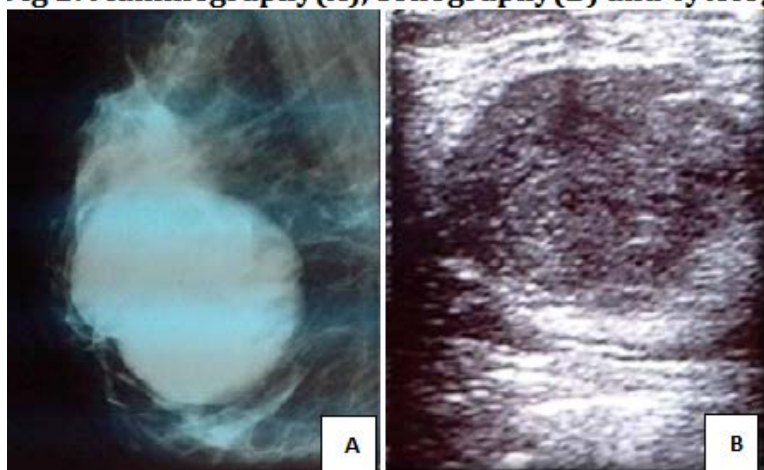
Mammography (A) and sonography(B) images of phylloides tumour
